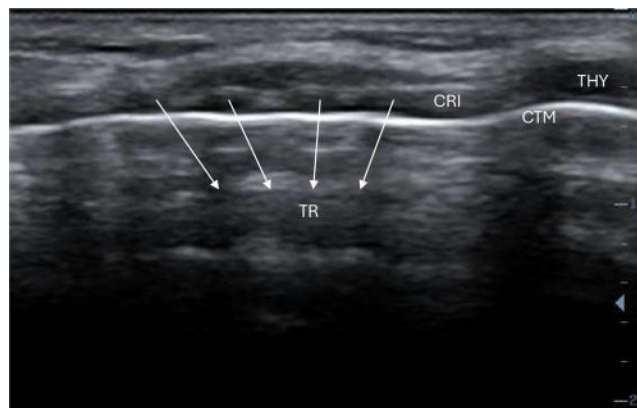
Ultrasound anatomy of the longitudinal view of the airway. TR, tracheal rings; CRI, cricoid cartilage; CTM, cricothyroid membrane; THY, thyroid cartilage (figure courtesy of Vinicius Quintao).
